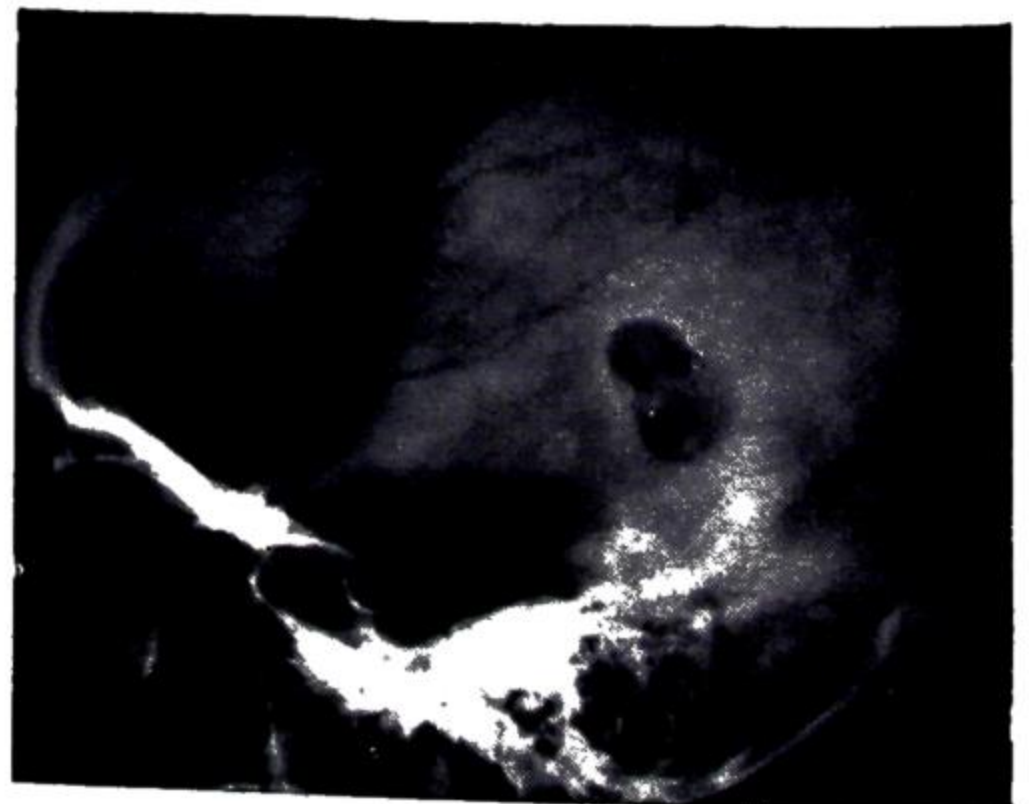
Lateral X-ray showing dermoid cyst of the diploë. The inner table has been penetrated by intracranial extension.
